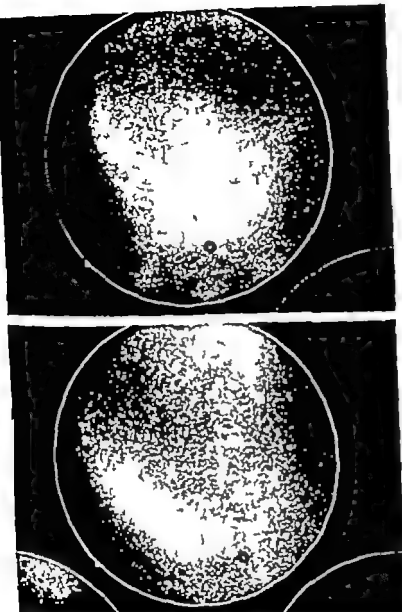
Frontal (above) and lateral scintigrams from patient with total placenta praevia. In both projections the marked internal cervical os is completely covered by the placenta.
